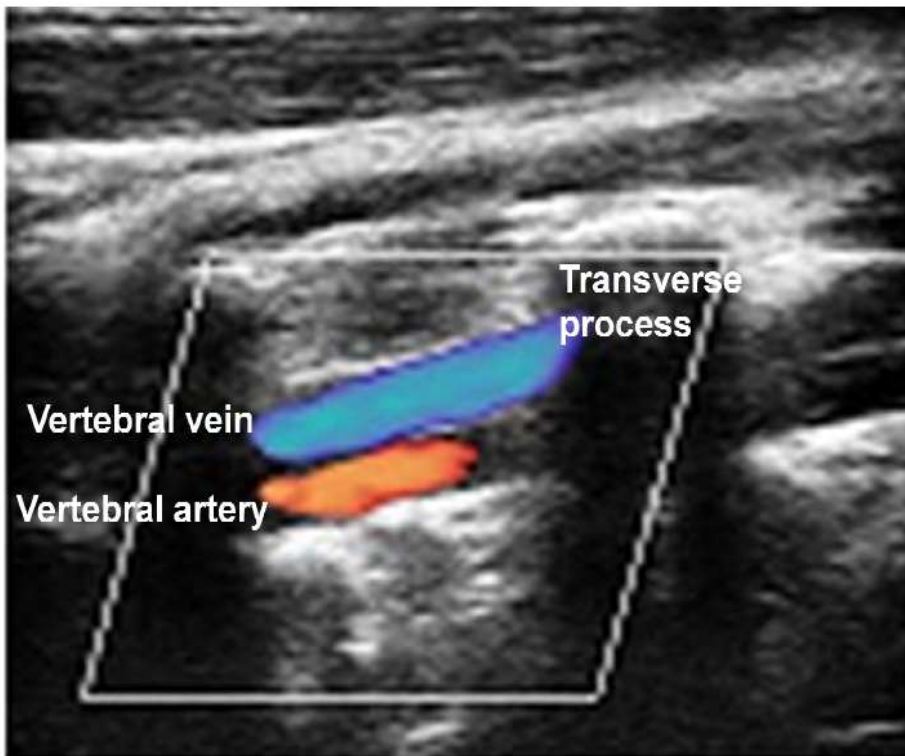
Vertebral artery, longitudinal section, colour-coded Doppler mode.
